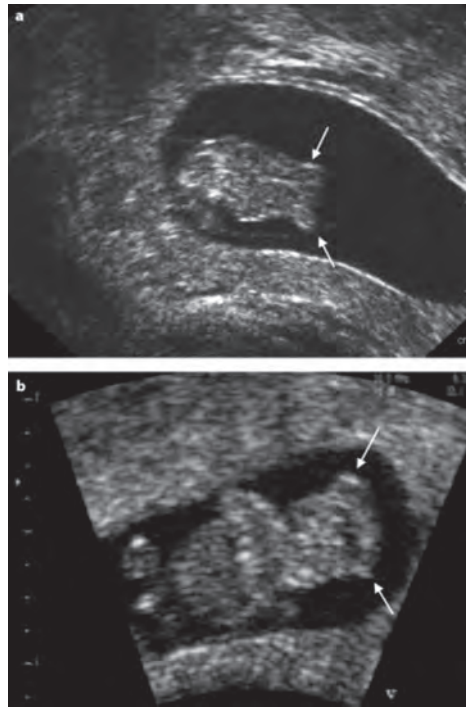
Sections through the heads of 'typical' exencephaly cases at CRL 22mm (A) and CRL 28 (B) visualized using two-dimensional transvaginal ultrasound. The irregular contours of the brain are indicated by the arrows. Reproduced with permission of John Wiley and Sons.
